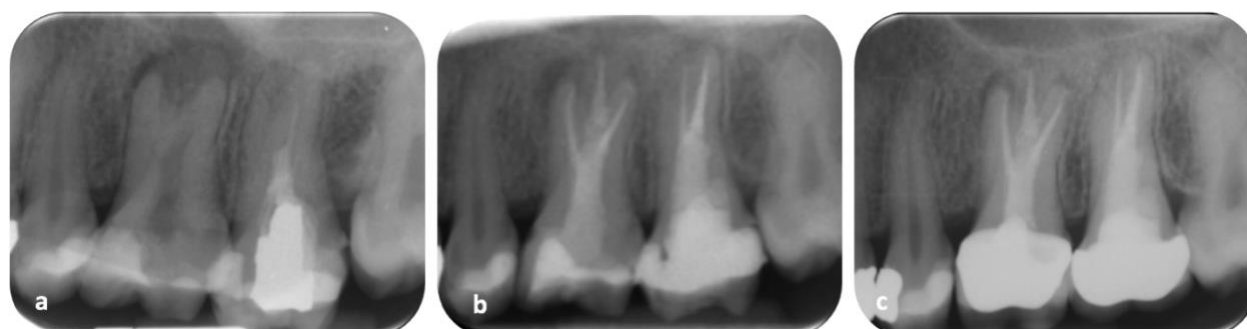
Review of teeth 26 and 27 (a) Pre-operative radiograph (b) Postoperative radiograph (c) 1-year review, showing periapical radiolucency is less dense
